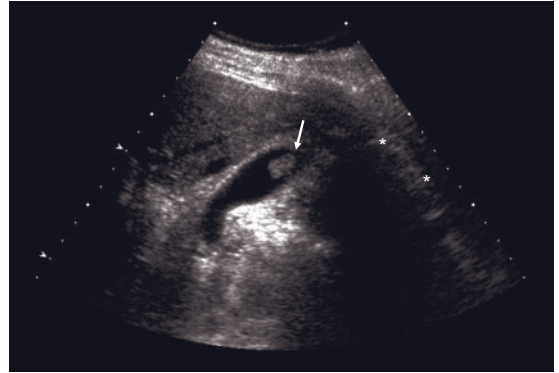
Ultrasound scan of gall-bladder adenoma: non-shadowing, fixed polypoid lesion measuring approximately 14 × 10 × 7 mm. Its large size suggests an adenomatous polyp. (Courtesy of Maitray D Patel, MD, Department of Radiology, Mayo Clinic, AZ.)
